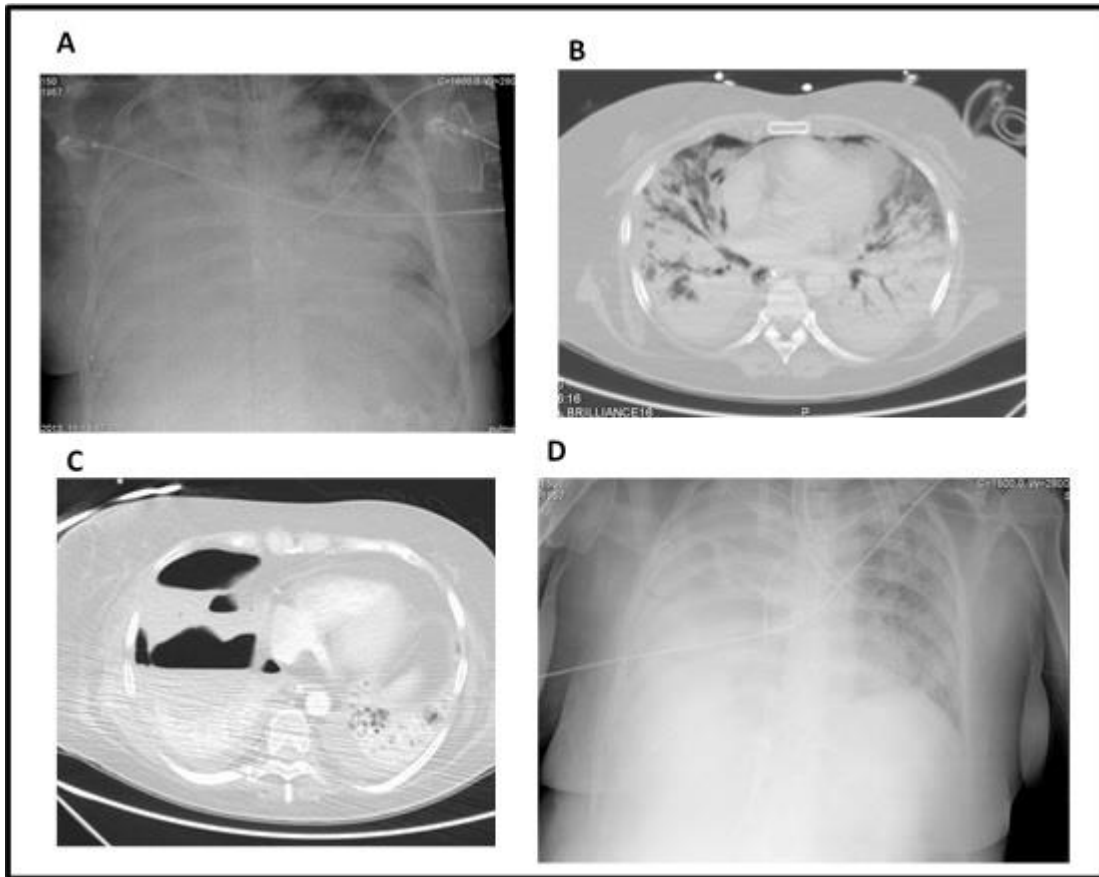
Chest X-ray (A) at admission at the Emergency room, Thoracic computed tomography (B) pre-ECMO and Chest X-ray of the last rheumatology consultation of patient 2. A. heterogeneous infiltrates in both inferior halves of the lungs. B. diffuse bilateral ground glass pattern with lobar consolidation and right pneumothorax. C. Complete resolution of bilateral infiltrates.
